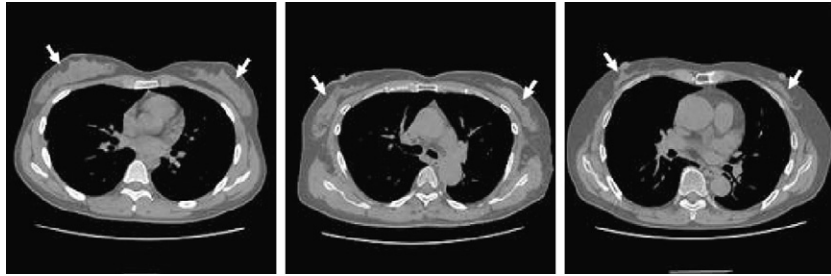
Examples of mammary gland regions in CT images from three female patient cases. White arrows show the locations of mammary gland region from left to right, 20, 56 and 70 years old.
